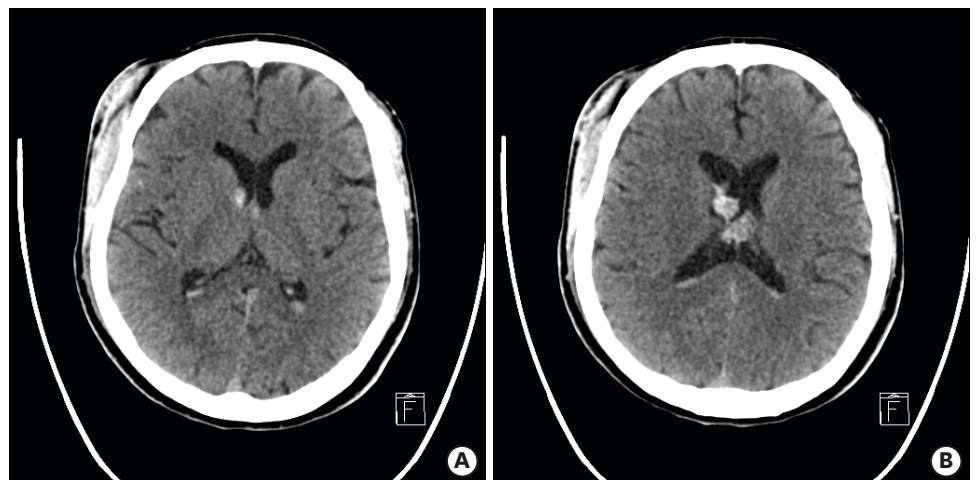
A repeat cranial computed tomography scan obtained 2 hours after the injury reveals increased amount of traumatic intraventricular hemorrhage in bilateral lateral ventricles and a much clearer traumatic intracerebral hemorrhage in the right temporal lobe.
